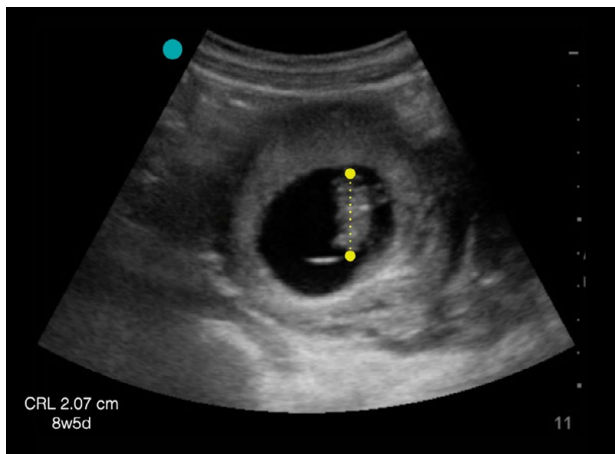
Ultrasound image showing the CRL with callipers for measurement. Note that the yolk sac is adjacent to but not included in the measurement. Image provided by Dr Sierra Beck.
